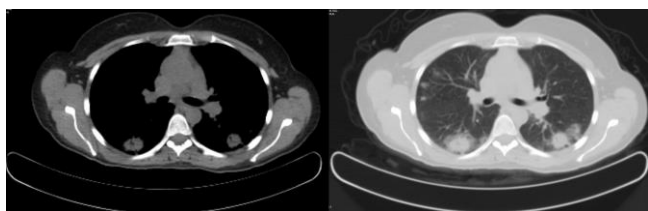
Thoracic CT showing widespread nodular opacities in both lungs
